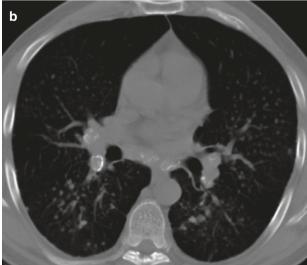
Silicosis with centrilobular nodules. (a) Axial CT image shows innumerable nodules: majority away from the pleural surface. (b) Axial CT image shows "egg-shell" calcification in hilar and mediastinal lymph nodes
